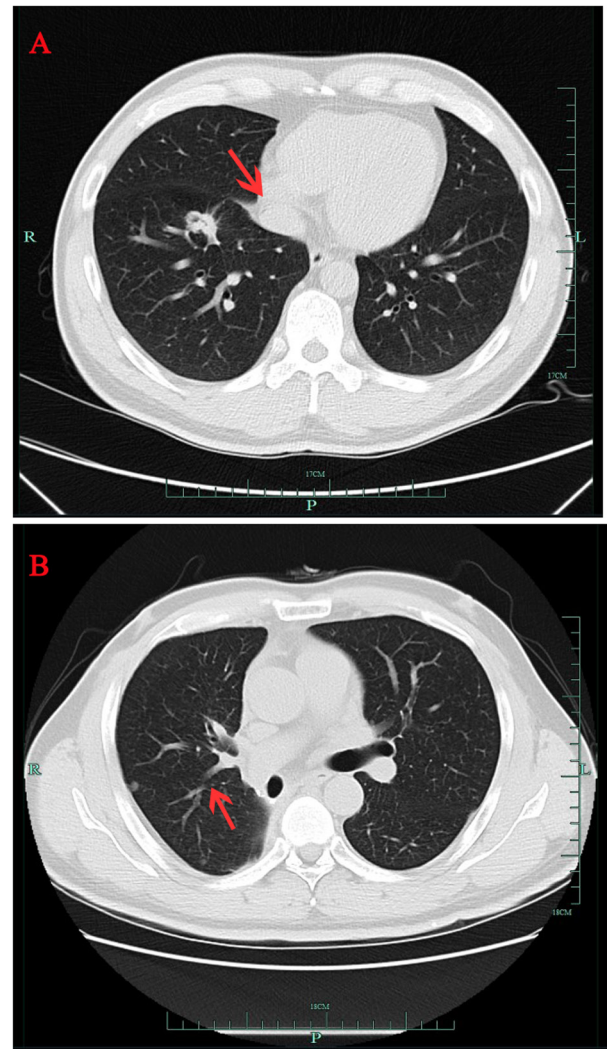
Serial chest CT scans of patient with non-small cell lung cancer. (A) CT scan from September 2016 showing a right lung mass (red arrow). (B) CT scan from March 2018 showing a small nodule (red arrow) near the pleura in the middle lobe of the right lung. CT, computed tomography.
